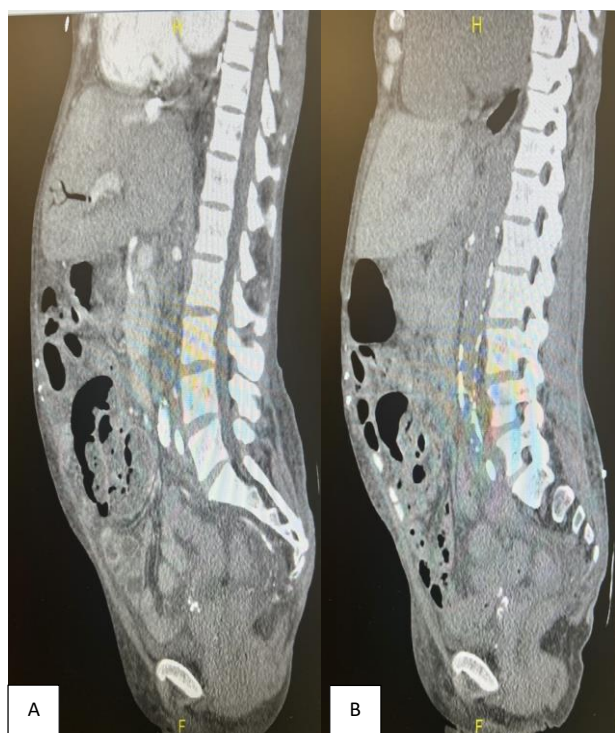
A) demonstrates initial CT scan and B) demonstrates repeat CT.
